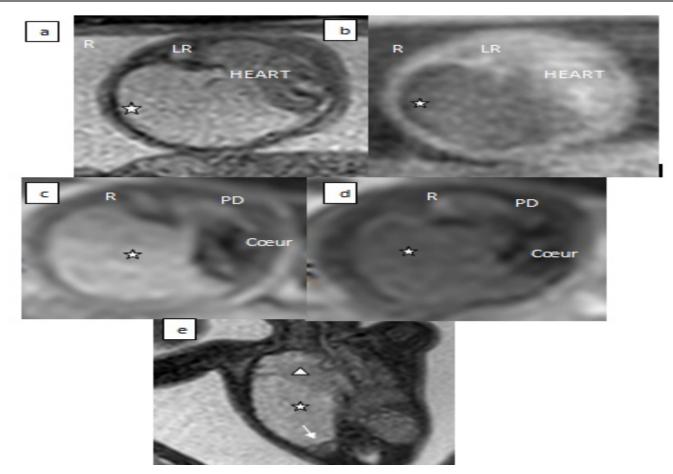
Fetal MRI performed at 28 weeks' gestation in T2 (a), T1 (b), T2 (a), diffusion (c) with ADC (d) and T2 coronal views: hypertrophy left (star) hyperintense in T2, hypo intense in T1 translating the water content of this pulmonary mass. The latter pushes the heart and the right lung (RL) towards the contralateral side. The coronal section objectifies the downward movement of the diaphragmatic cupola (arrow) and the right kidney. Presence of a triangular shaped beach, in discrete hyper signal pressed against the mediastinum (triangle) In front of the presence of two thoracic malformations, a pluridisciplinary consultation meeting and after talks with the parents had decided to continue the pregnancy. Close ultrasound monitoring was performed. It aimed to monitor the vitality and fetal growth as well as the appearance of complications including cardiac and pleuropulmonary.
